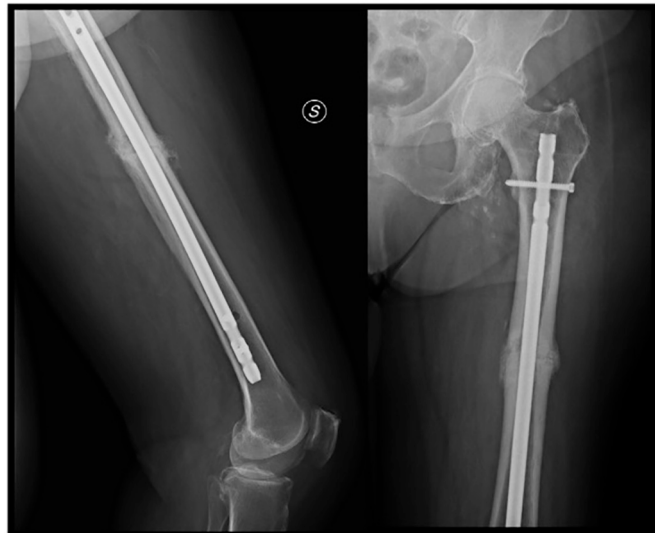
Left femur 4-months follow-up radiographs showing bone healing with callus formation. Left: lateral left femur. Right: antero-posterior left femur.
